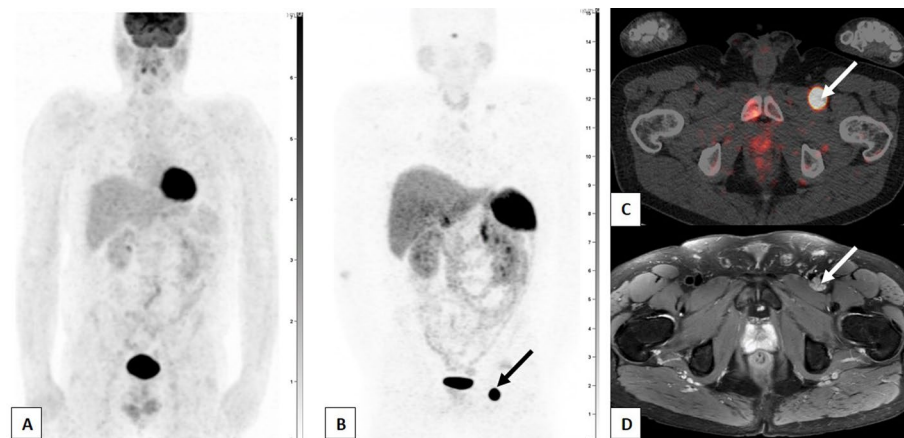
Whole-body maximum intensity projection (MIP) image of an ^{18}F -FDG PET/CT scan showing the physiological distribution of the radiotracer with no signs of abnormal hypermetabolic activity (A), followed by ^{68}Ga -DOTATATE PET/CT scan revealing intense radiotracer uptake (high somatostatin receptor overexpression) in a soft tissue left inguinal nodule (arrows) as seen on whole-body MIP (B) and axial fusion (C) images. It later confirmed as a nodule with high signal intensity on T2 weighted fat saturated magnetic resonance images (D, arrow), consistent with a small phosphaturic mesenchymal tumor in a patient with tumor-induced osteomalacia
